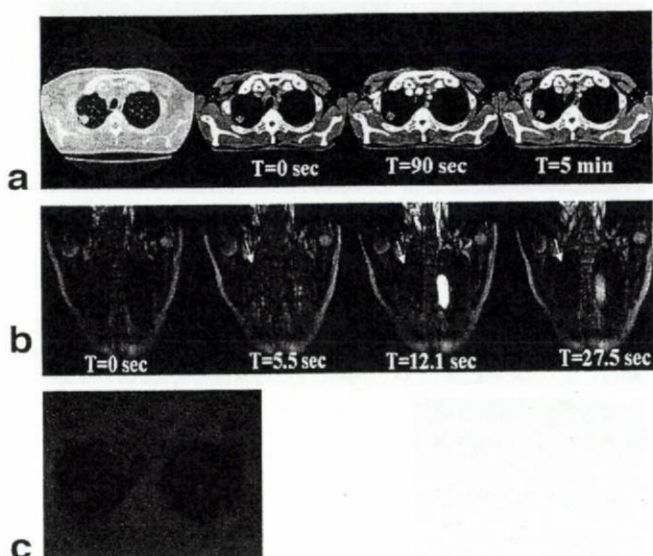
A 79-year-old male with primary lung cancer (adenocarcinoma) in the right lower lobe. a: Routine CT shows a nodule with a diameter of 25 mm in the right lower lobe. T indicates the time after bolus injection of contrast media. On dynamic CT, maximum enhancement, net enhancement, slope of enhancement, and absolute loss of enhancement are 73.2 HU, 32.4 HU, 0.54 HU/second, and 10.7 HU, respectively. This case is true-positive on dynamic CT indices. b: Dynamic MR images demonstrate enhancement of the nodule (arrow). T indicates the time after bolus injection of contrast media. Maximum relative enhancement ratio is 0.36 and slope of enhancement ratio is 0.065/second. This case is true-positive on both dynamic MR indices. c: Coregistered PET/CT demonstrates high uptake of FDG, and  $SUV_{max}$  of the lesion is 3.8. This case is true-positive on coregistered PET/CT.
